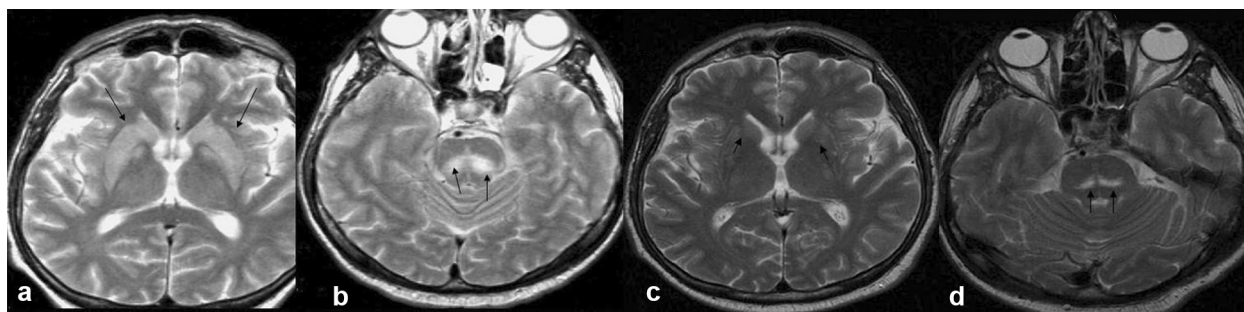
a; Axial T2 MRI revealed T2 hyperintense signal changes in the caudate nucleus, globus pallidus and putamen, b; as well as in the mesencephalon region, including nucleus ruber and the periphery of nucleus ruber, c; The follow-up cerebral T2 axial revealed the increased signal to disappear in the caudate nucleus, globus pallidus and putamen, d; however, the increased signal persisted in the mesencephalon region.
